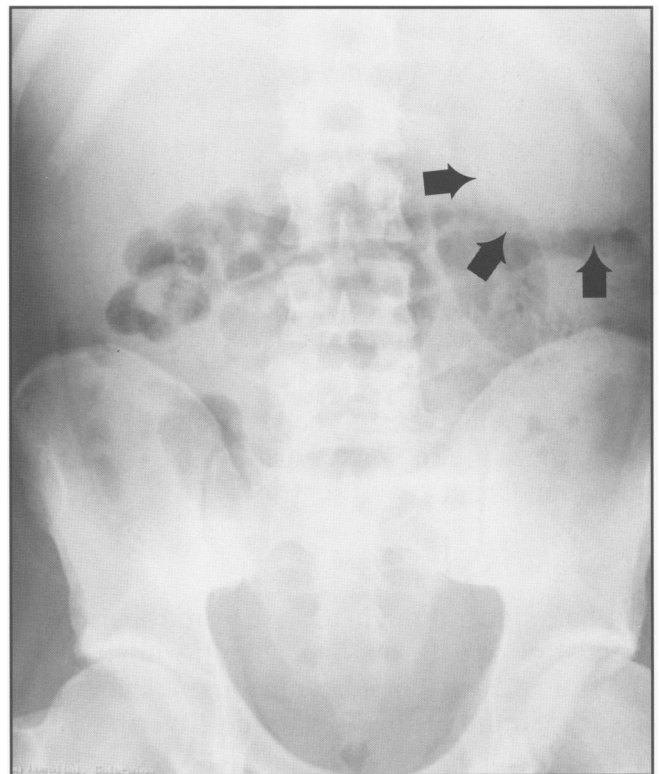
Abdominal radiograph demonstrating enlarged spleen.
